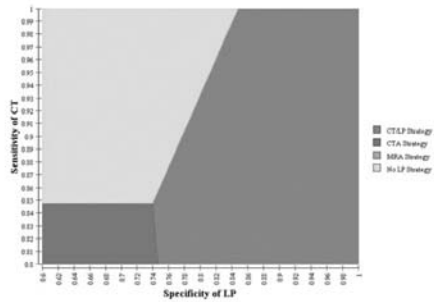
Results of a two-way sensitivity analysis comparing sensitivity of CT to specificity of LP. CT = computed tomography; CTA = CT angiography; LP = lumbar puncture; MRA = magnetic resonance angiogram.
